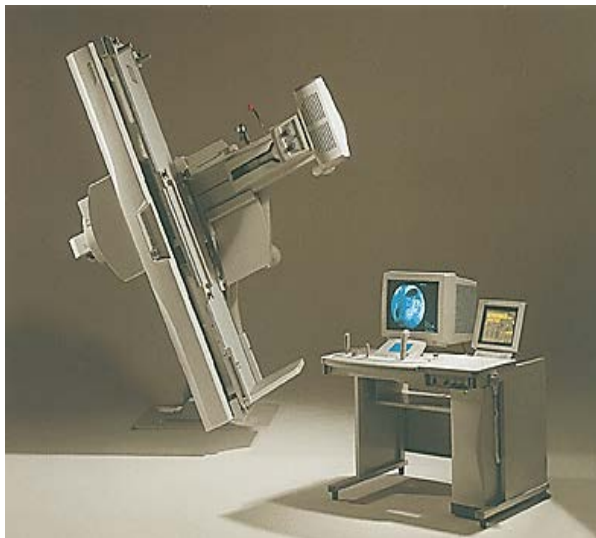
Modern x-ray machine.
